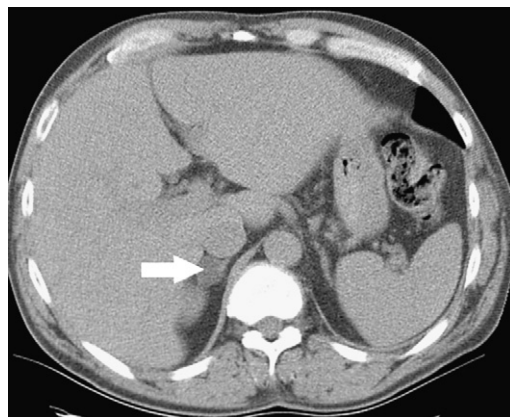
Low-density adenoma. Right adrenal mass (arrow) measuring 6 HU on noncontrast CT representing a pathologically proved adenoma.
